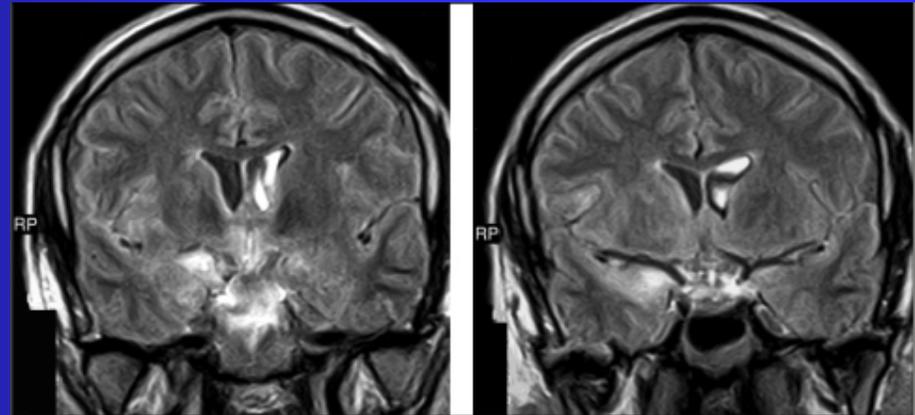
MRI images after gadolinium contrast injection: patchy contrast enhanced lesions in the insula and hippocampus in the right and in the hypothalamic-diencephalic region.
